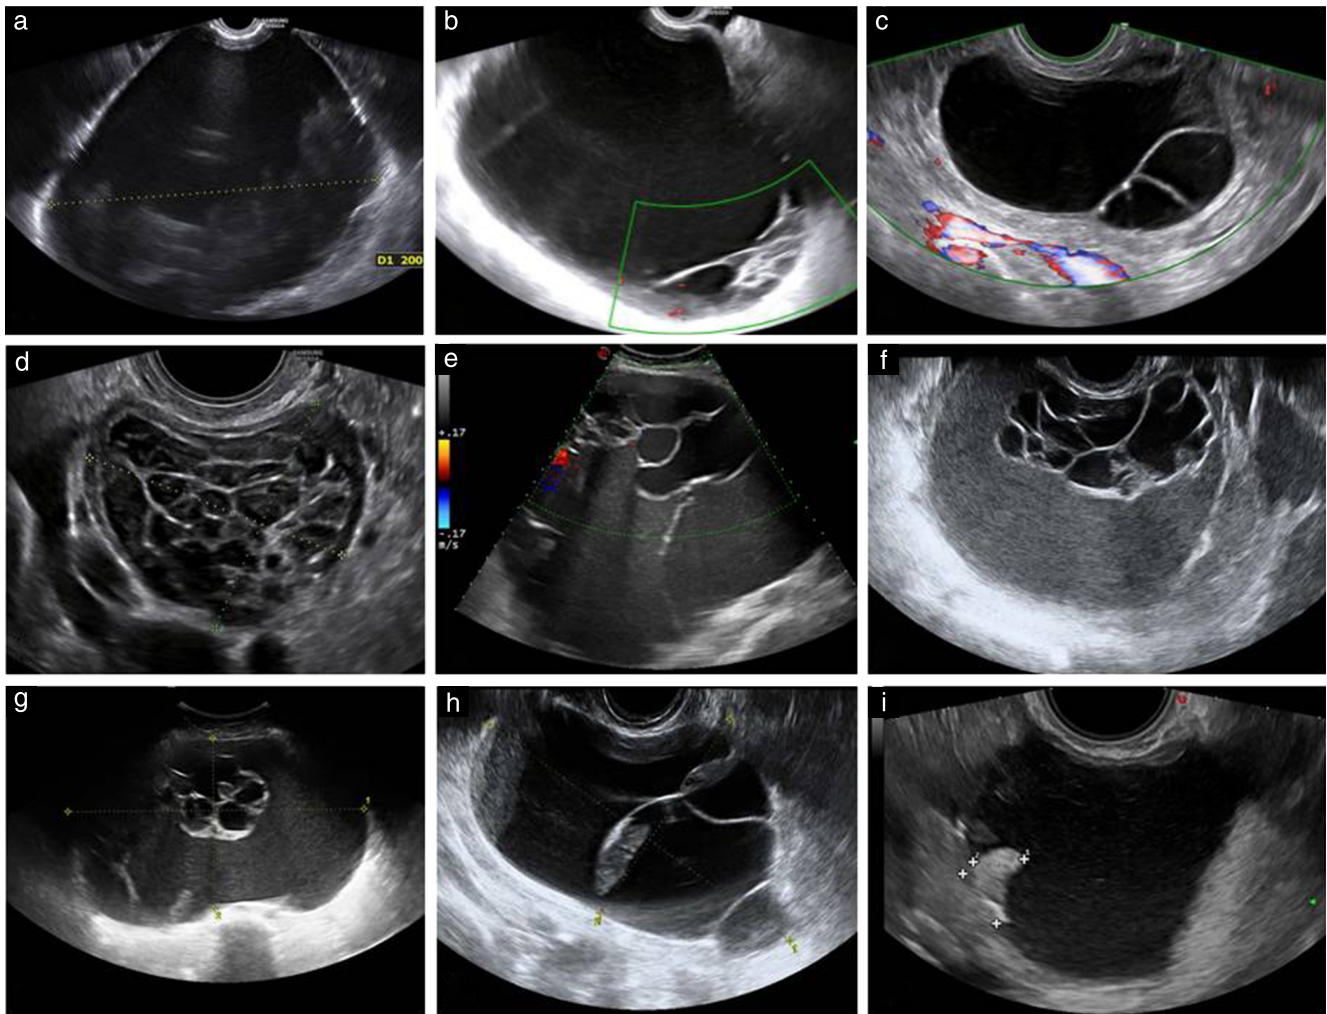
Ultrasound images of benign mucinous cystadenomas, presenting as unilocular (a), multilocular (b–g), multilocular-solid (h) or unilocular-solid (i) cysts, the majority being multilocular with 2–10 locules (b,c) or > 10 locules (d–g). Honeycomb nodule can sometimes be visualized (g). Lesions in (a–e) were diagnosed correctly by ultrasound examiner as benign, mass in (f) was misdiagnosed as borderline, masses in (g,h) were misdiagnosed as invasive and mass in (i) had uncertain diagnosis.
